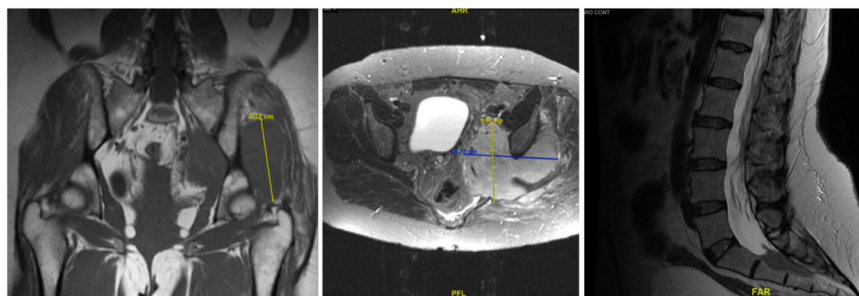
Pelvic MRI without contrast T1 coronal (left) and axial (middle) showing mass measuring $11 \times 9 \times 8$ cm infiltrating the lower lumbosacral plexus, sciatic nerve and surrounding pelvic and gluteal musculature. Lumbosacral spine MRI without contrast T2 sagittal image (right) showing recurrence of lymphoma with new invasion of the sacral canal.
